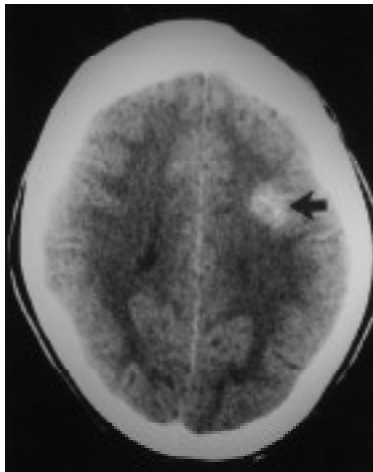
Unenhanced CT scan of the brain in a 26-year-old woman presenting with a 2 year history of generalised seizures shows a focal hyperdense lesion in the left parietal lobe with focal calcification (arrow) within the lesion. There was no mass effect or surrounding oedema.
